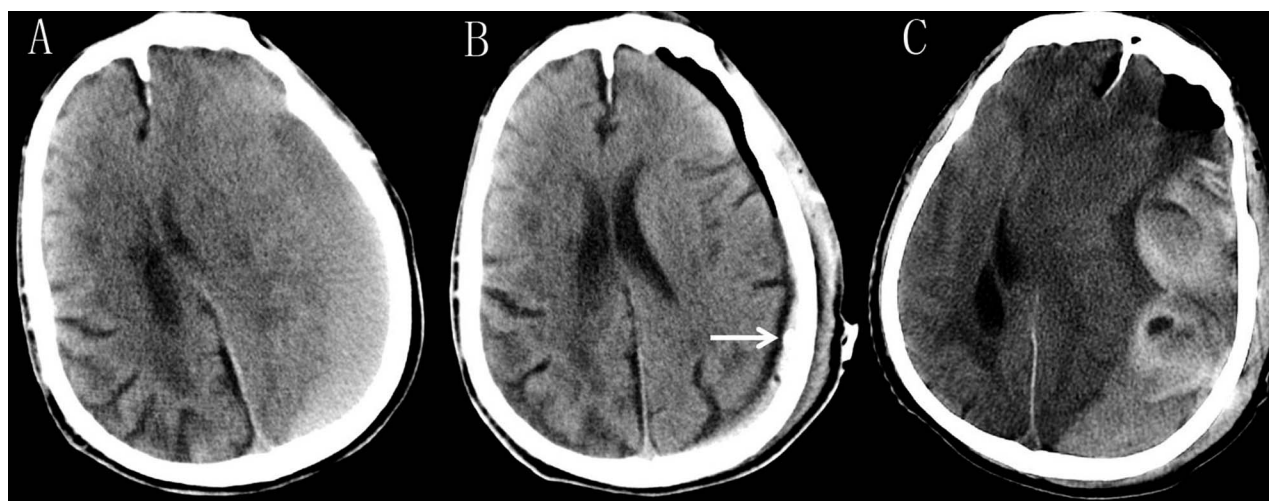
(A) Axial CT imaging showing a thick subacute subdural hematoma in the left cerebral hemisphere. (B) Axial CT imaging showing the majority of the hematoma was removed after a burr hole drainage and a catheter was placed in the subdural cavity (arrow). (C) Axial CT imaging showing a massive fresh subdural hematoma with significant midline shift right after the catheter removal.
